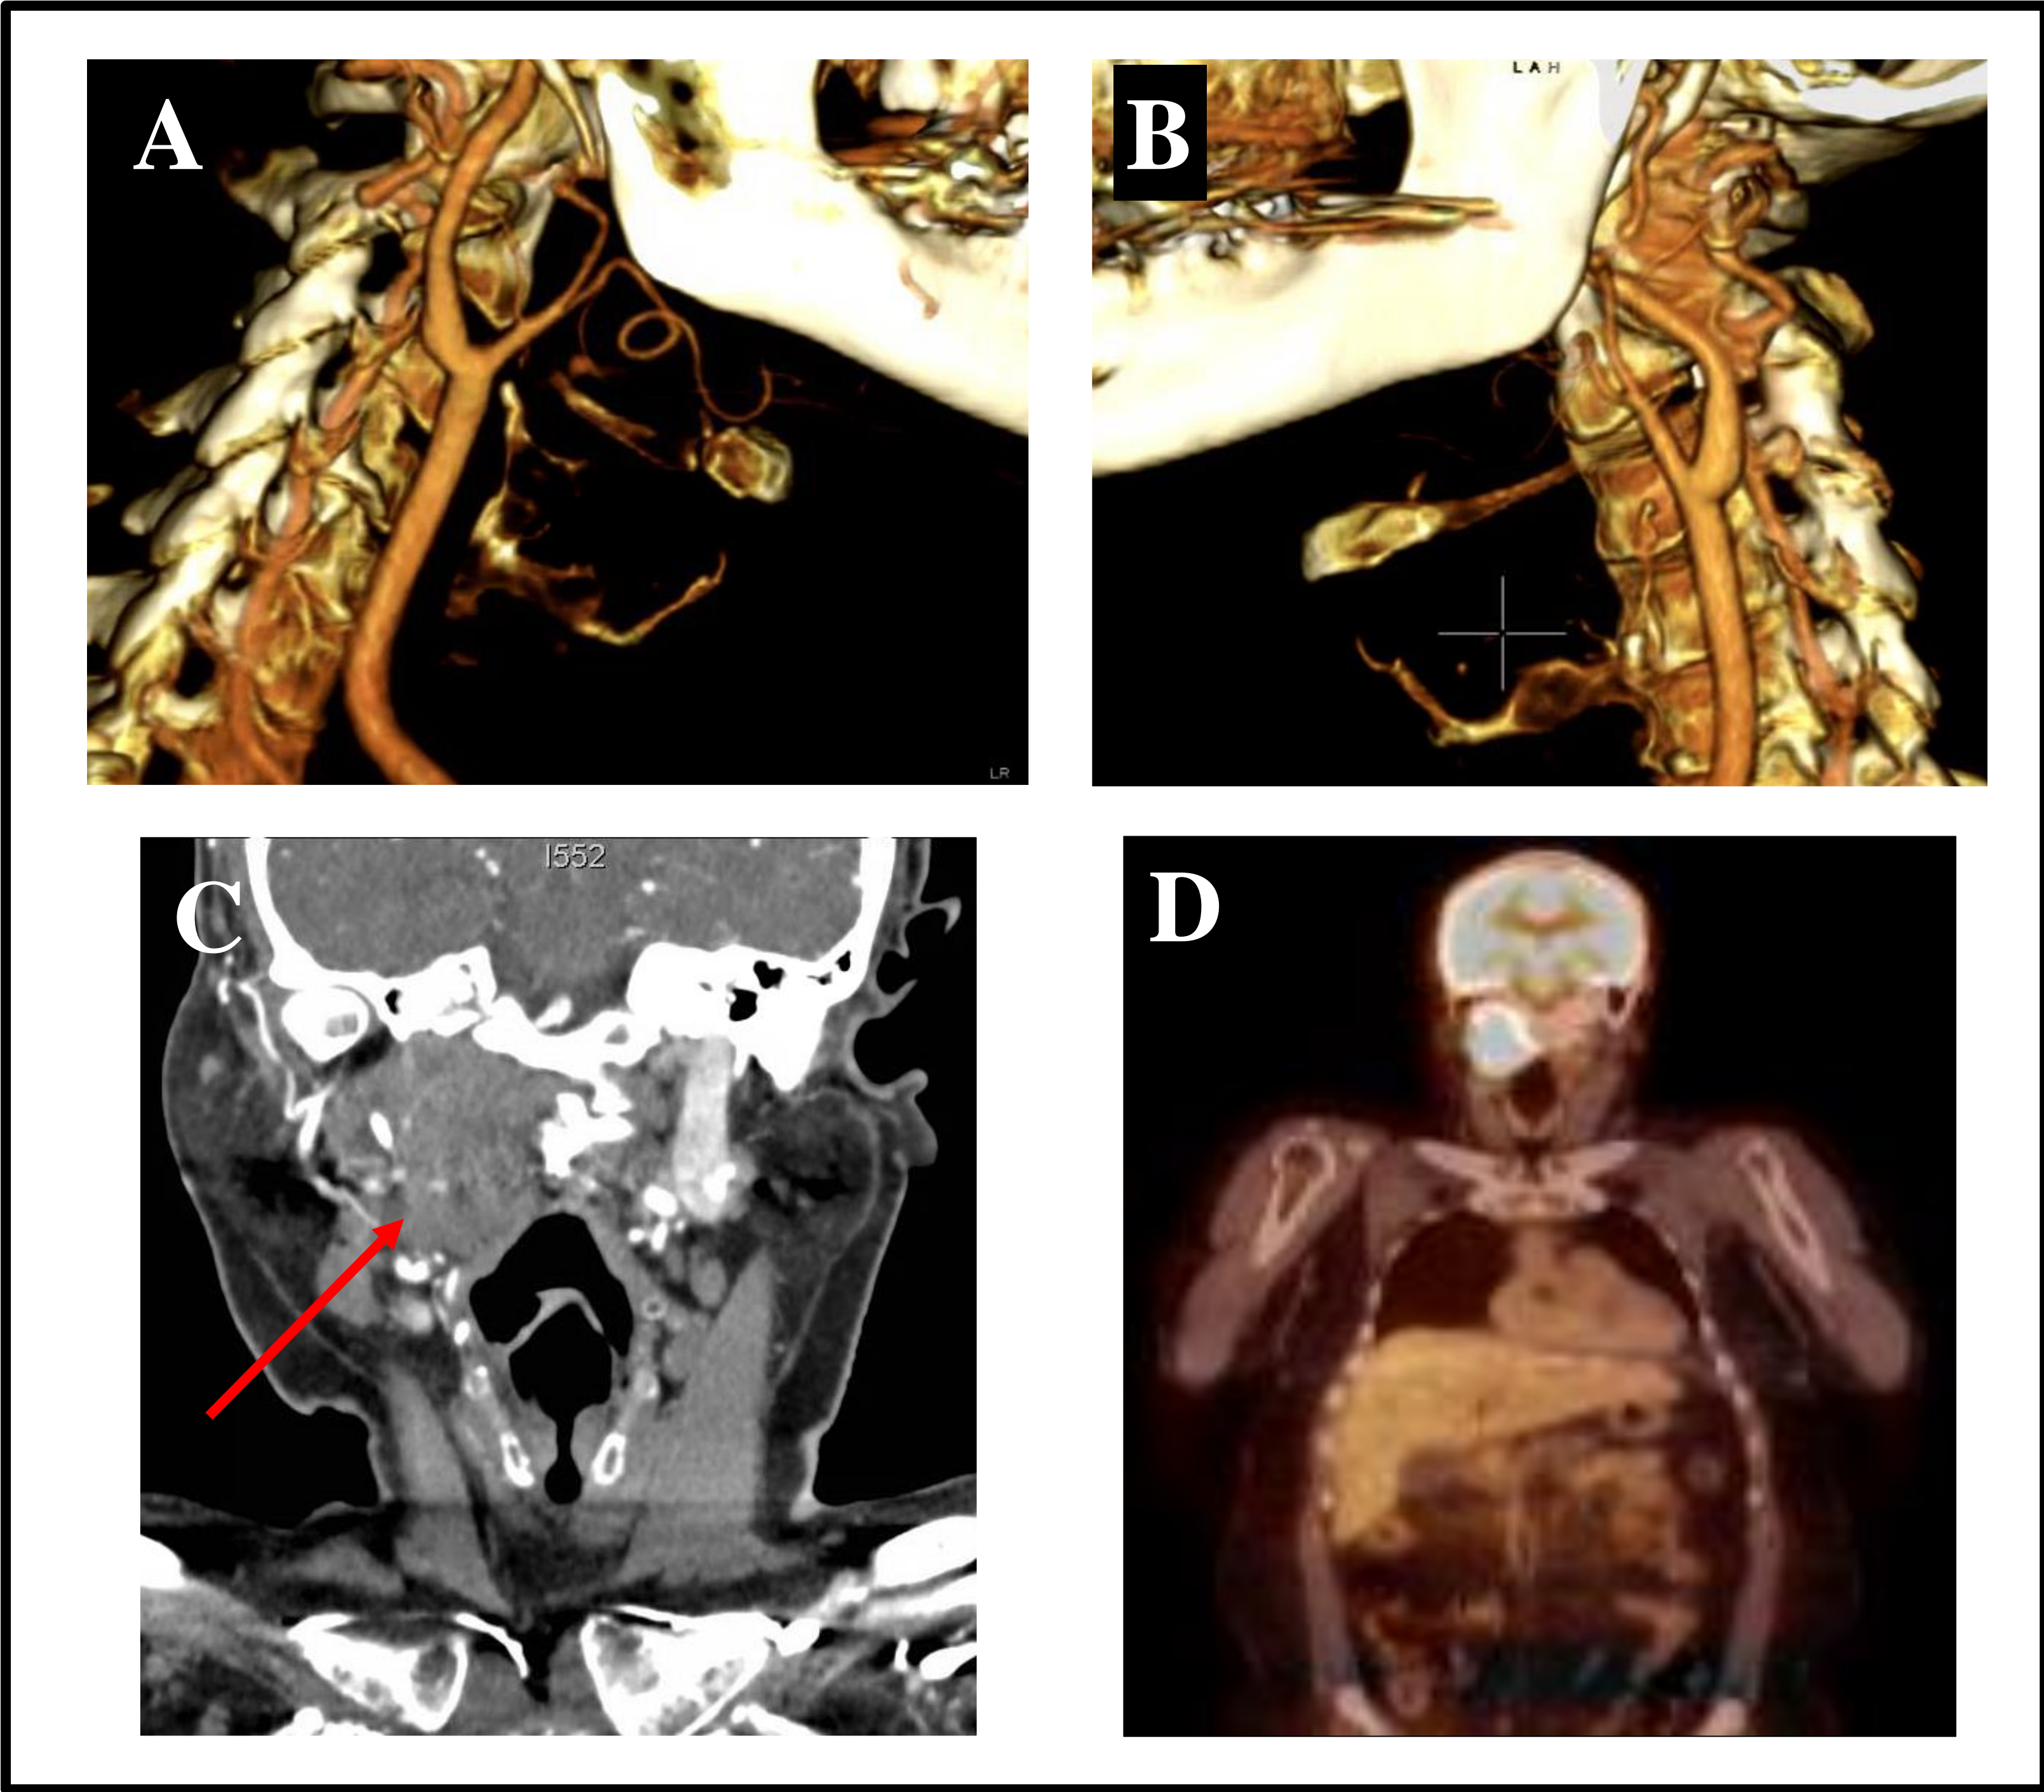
3D reconstruction of carotid vasculature showing splaying of the right internal and external carotid arteries (A) as compared to the left (B). CT-A neck showing large soft tissue mass involving the right styloid parapharyngeal space (C). PET scan showing intense abnormal uptake corresponding to the right parapharyngeal mass (D).
